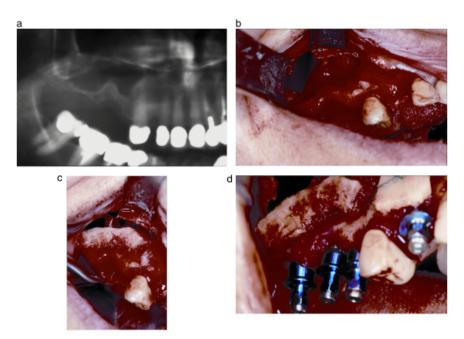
Sinus membrane perforations >10 mm were treated with a block graft harvested from the mandible. (a) Pre-operative panoramic radiograph showing the presence of antral septa in the posterior right maxilla. (b) Perforation of the sinus membrane is observed. (c) A mandibular bone block is placed against the perforated site to repair the sinus membrane. (d) Stabilization of the bone block graft with three implants, which are used to achieve initial stability of the bone graft and implants.
